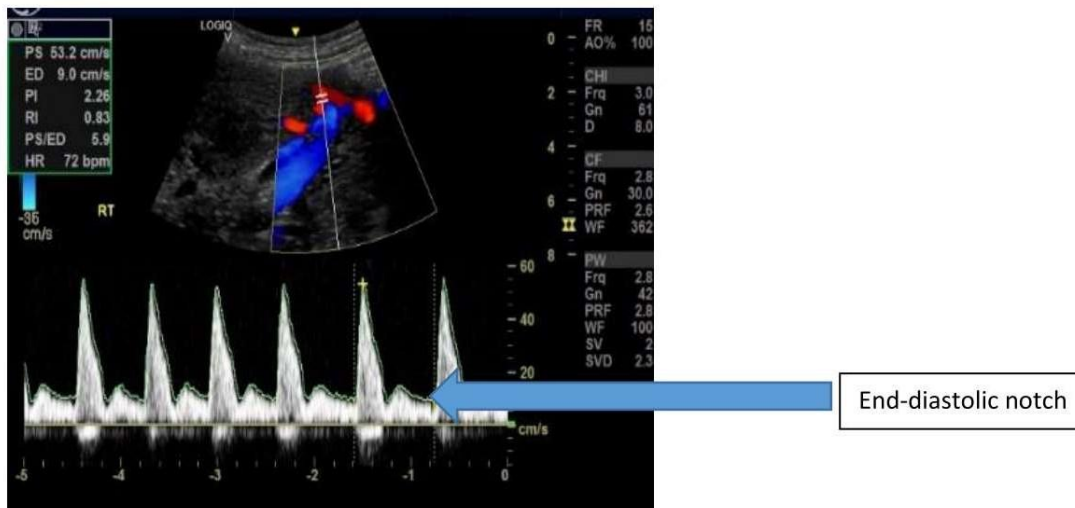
Abnormal uterine artery Doppler flow tracing
